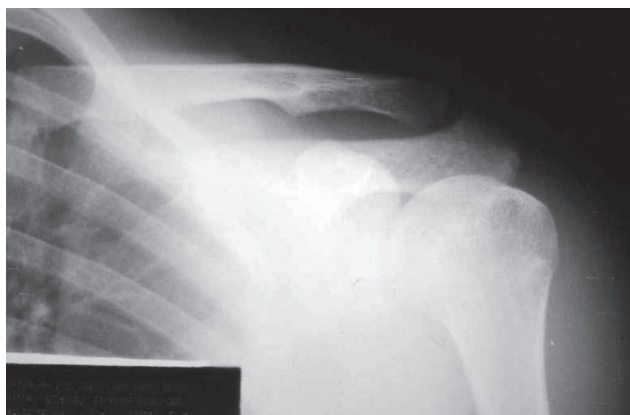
Anteroposterior radiograph on patient with tropical pyomyositis in the left deltoid muscle, showing increased size of soft tissue
